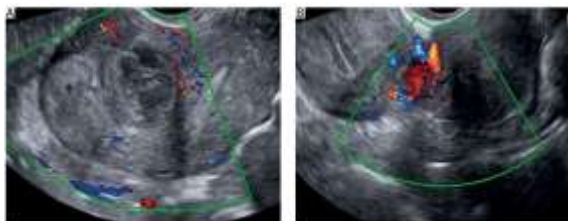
Represents the vascularity pattern of uterine leiomyoma on color doppler.<sup>17</sup>
